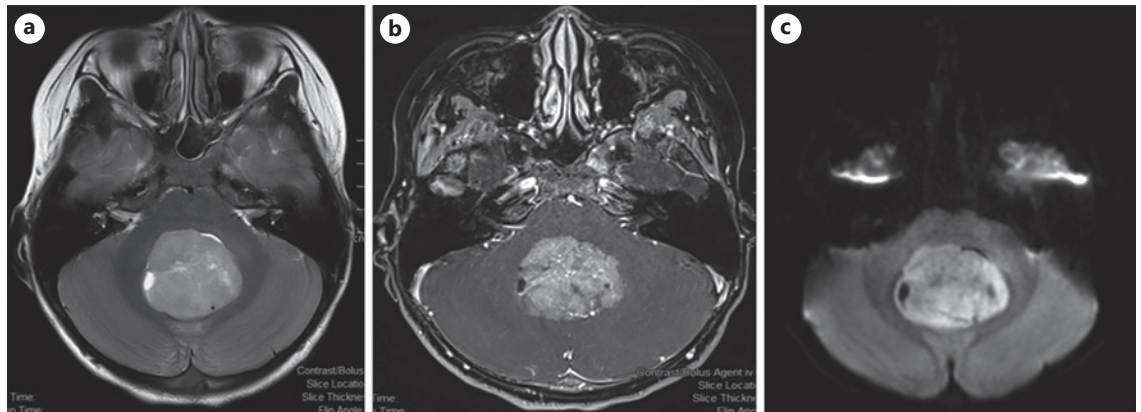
T2-weighted image showing a hyperintense mass located in the midline of the posterior fossa (a); Gadolinium-enhanced axial T1-weighted image showing presence of a tumor with well-defined margins and solid enhancement originating from the vermis of the cerebellum and extending into the fourth ventricle (b); Medulloblastomas are characterized by high signal in DWI and low ADC values (c). DWI, diffusion-weighted; ADC, apparent diffusion coefficient.
